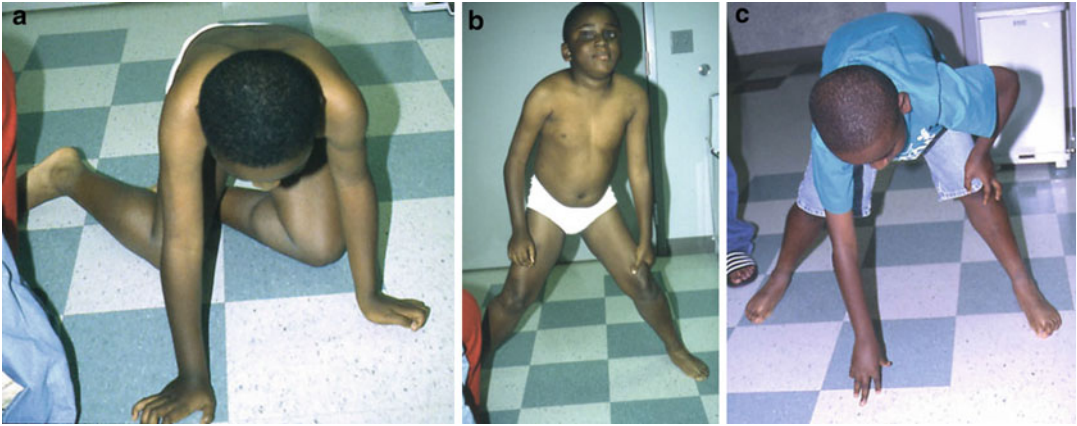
(a–c) A 10-year-old boy with DMD showing Gower sign maneuver. He walked before 16 months of age and had trouble getting up. Radiography showed
